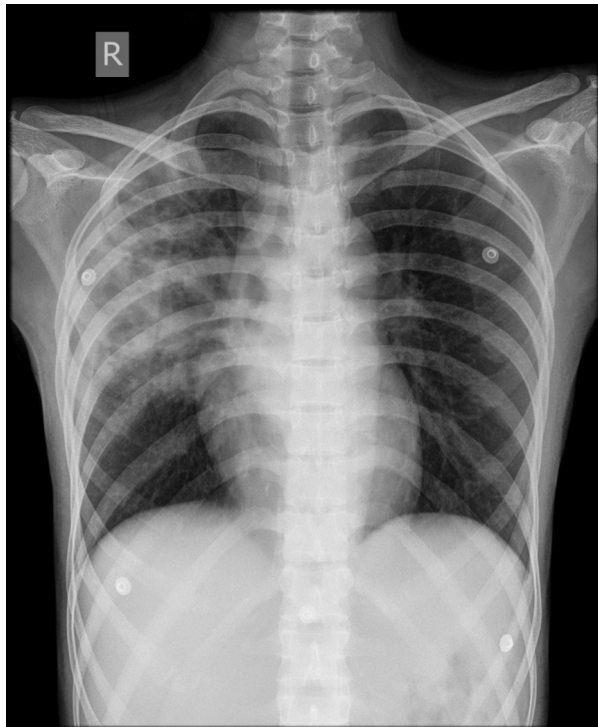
Chest X-ray showing right upper and middle zone opacities.
